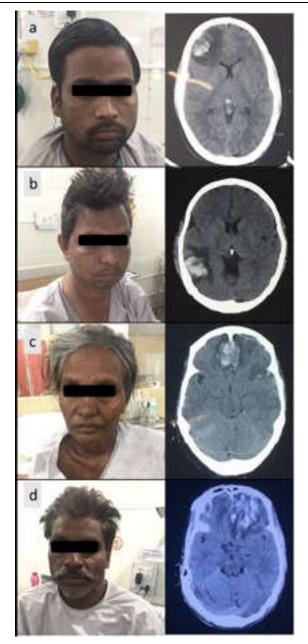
Clinical photographs with respective adjacent CT Brain images of Cases 2.3.4 & 5
